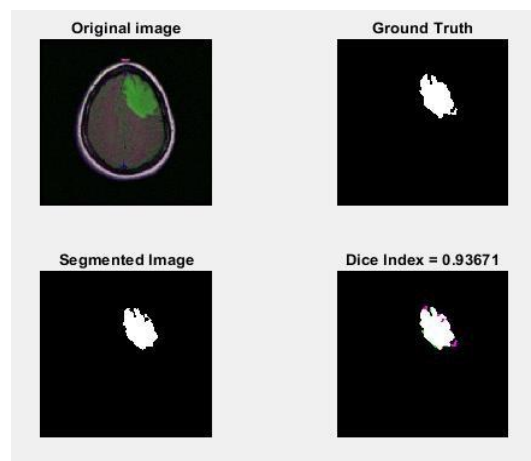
Segmented result for LGG MRI 6
